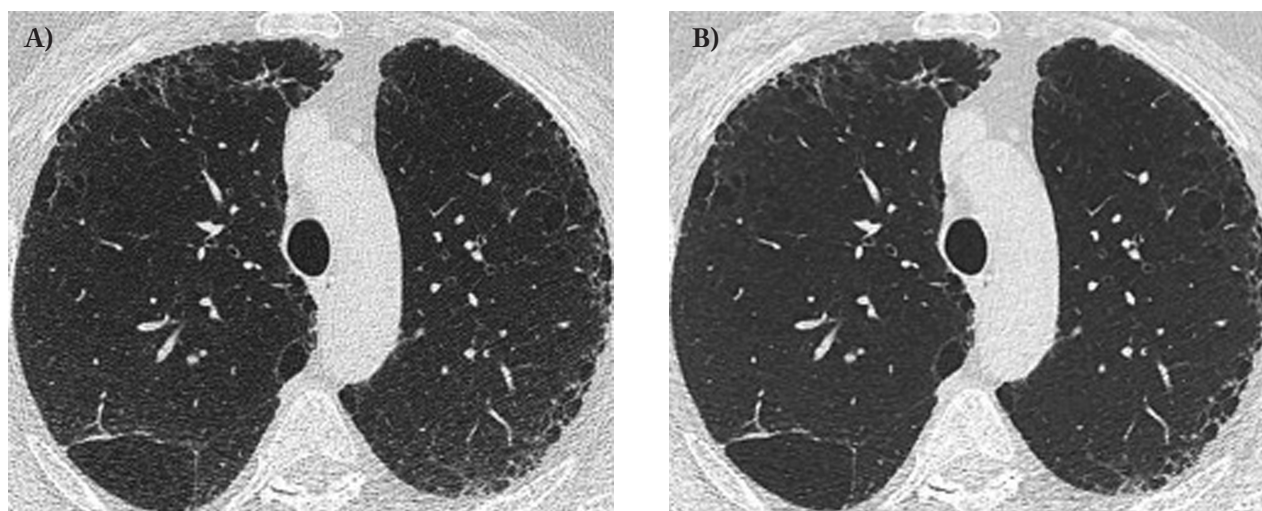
Intralobular reticular opacities in transverse CT image reconstructed with A: filtered back projection and B: SAFIRE 4
